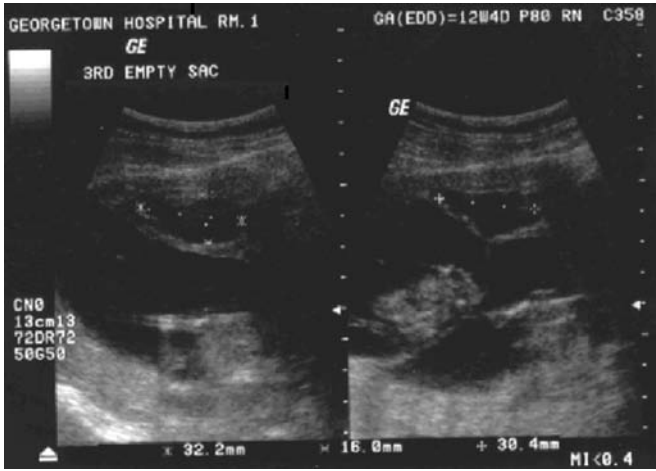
Sonogram demonstrating a third empty sac (measuring 32.2 × 16.0 × 34.4 mm) in a previously viable triplet gestation.
